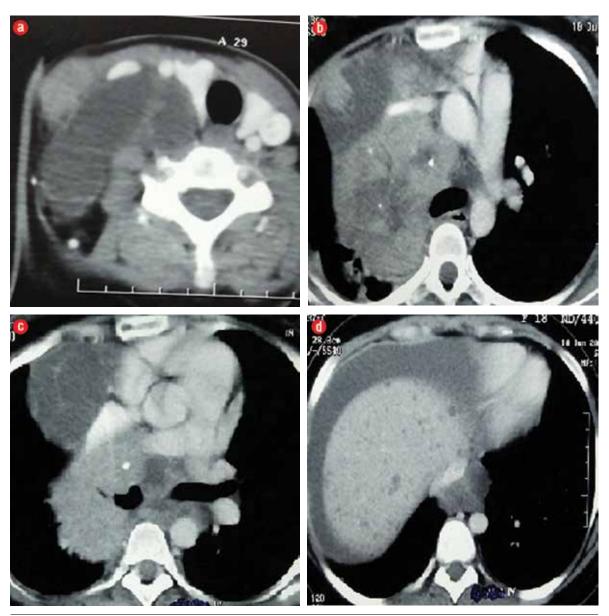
Computed tomography of the thorax after four years showing large lobulated inhomogeneous enhancing mass. (a) Extending to the right side of the neck. (b) Mediastinal mass lesion occupying retrosternal, prevascular, pretracheal, right paratracheal, precarinal, subcarinal, paraesophageal, right hilar, and infra hilar region. (c) Mediastinal mass lesion causing compression and displacement of proximal superior vena cava and right main pulmonary artery. (d) Multiple small hypodense lesions in the liver with ascites.
